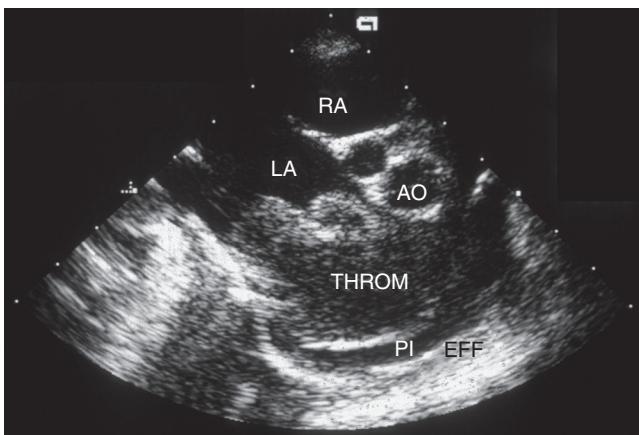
Right-parasternal short-axis echocardiographic image demonstrating a huge left atrial thrombus.
